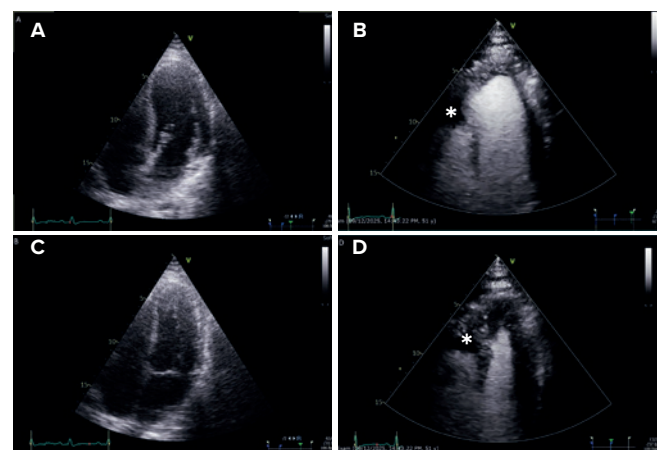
Comparison between initial echocardiogram and contrast echo – a) Initial echo apical 4 chamber in diastole; b) Contrast echo apical 4 chamber in diastole; c) Initial echo apical 4 chamber in systole; d) Contrast echo apical 4 chamber in systole; *) filling defect in the right ventricle
